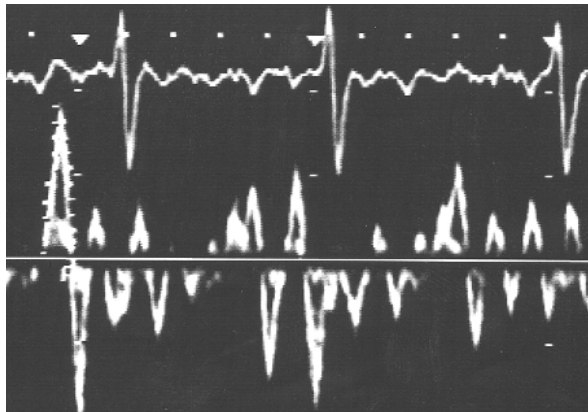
Doppler velocity flow in LAA during the atrial fibrillation
